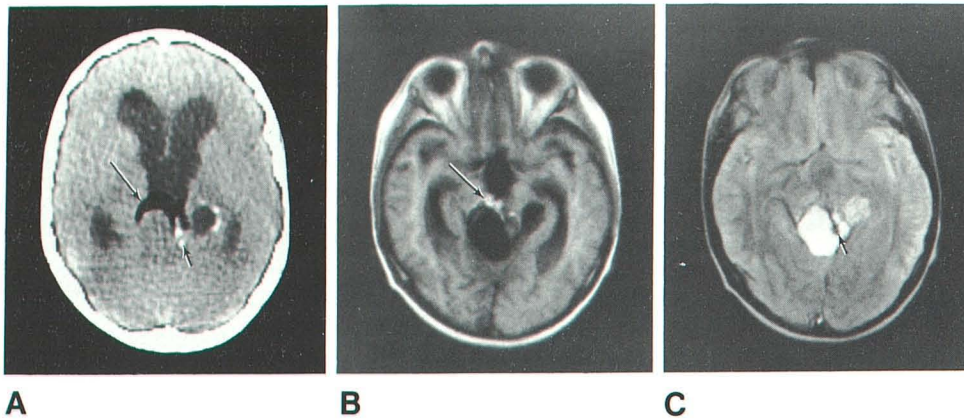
Dermoid cyst after partial resection and radiotherapy. Contrast-enhanced CT (A), IR 1500/500/44 (B), and SE 1580/80 (C) images. A, Area of low attenuation (*long arrow*) and calcification (*short arrow*) is seen in region of pineal gland. B and C, Short T1 component of tumor (*long arrow*) is anterior to area of long T1 and T2, consistent with cyst. A and C, Calcification has low signal intensity on MRI (*short arrows*). Moderate hydrocephalus is present on all scans. (CT scan [A] is more steeply angulated than MR scans [B and C].)
